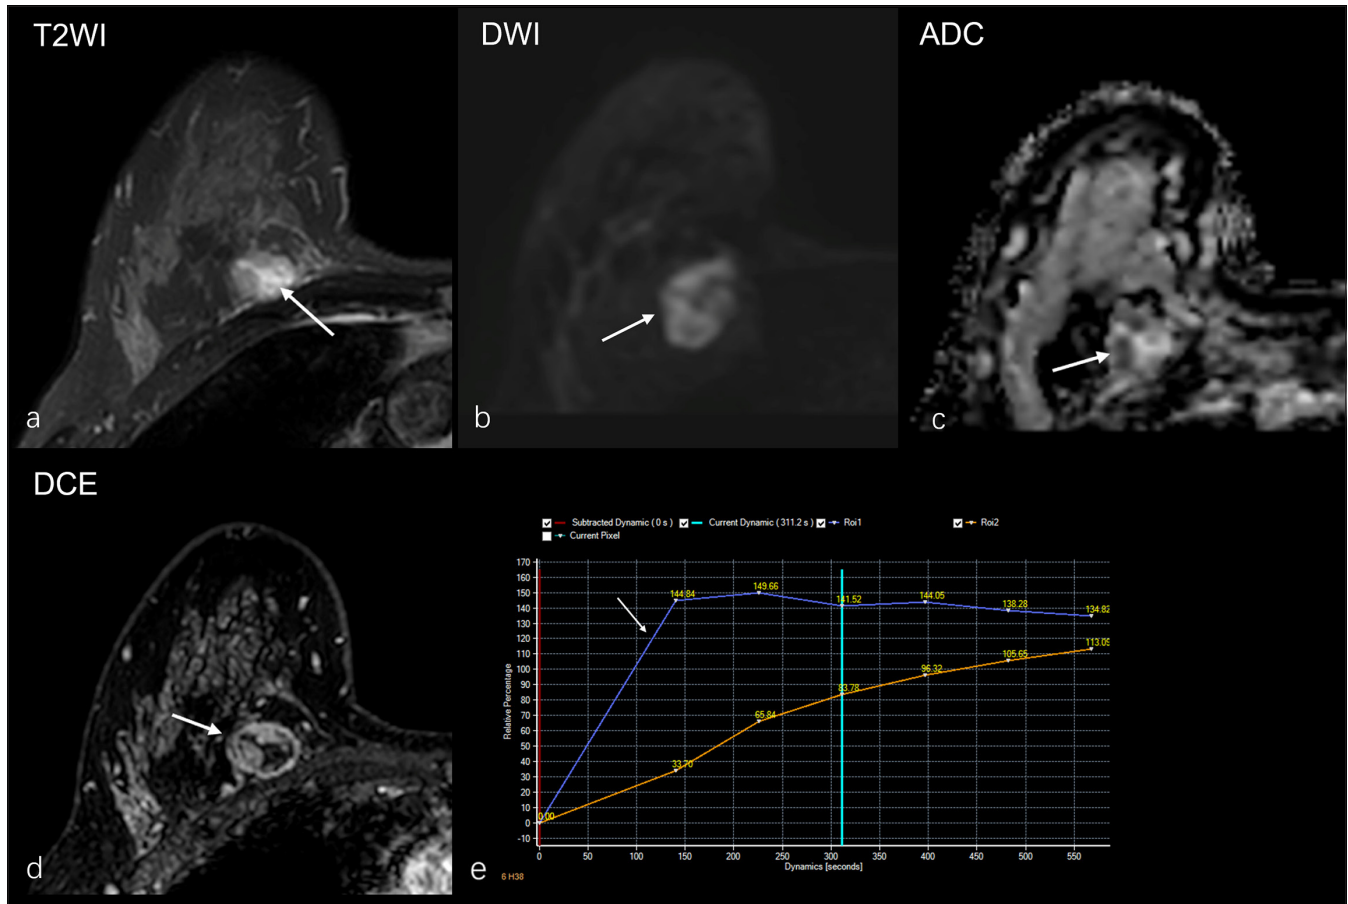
A 35-year-old woman diagnosed with invasive ductal carcinoma of the triple-negative breast cancer. (a) The lesion presents uneven high signal on T2-weighted imaging (white arrow), (b) circular high signal on diffusion-weighted imaging (white arrow), (c) corresponding circular low signal on apparent diffusion coefficient (ADC) mapping (white arrow), the average ADC value of the solid part is $0.84 \times 10^{-3} \text{mm}^2/\text{s}$. (d) The initial phase of dynamic contrast enhancement shows a round regular ring enhanced mass with smooth margin (white arrow), (e) the kinetic curve (white arrow) demonstrates a plateau appearance (type II curve). (T2WI: T2-weighted imaging, DWI: Diffusion-weighted imaging, DCE: Dynamic contrast enhancement)
